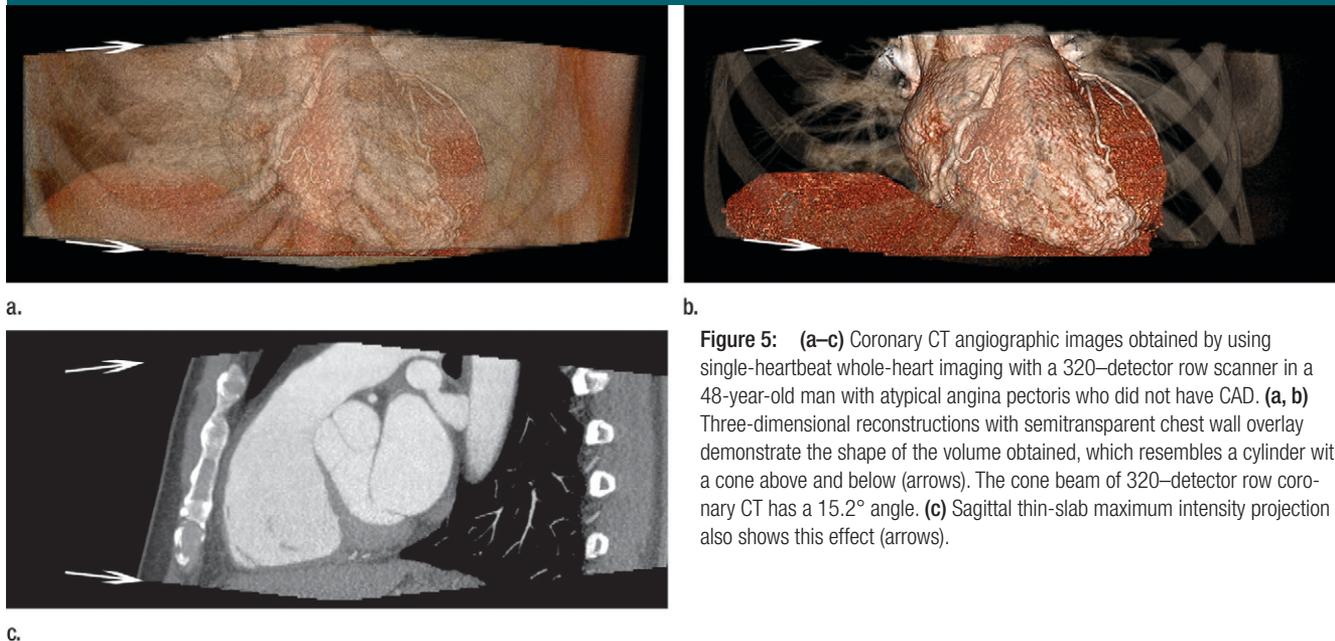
(a–c) Coronary CT angiographic images obtained by using single-heartbeat whole-heart imaging with a 320–detector row scanner in a 48-year-old man with atypical angina pectoris who did not have CAD. (a, b) Three-dimensional reconstructions with semitransparent chest wall overlay demonstrate the shape of the volume obtained, which resembles a cylinder with a cone above and below (arrows). The cone beam of 320–detector row coronary CT has a 15.2° angle. (c) Sagittal thin-slab maximum intensity projection also shows this effect (arrows).
